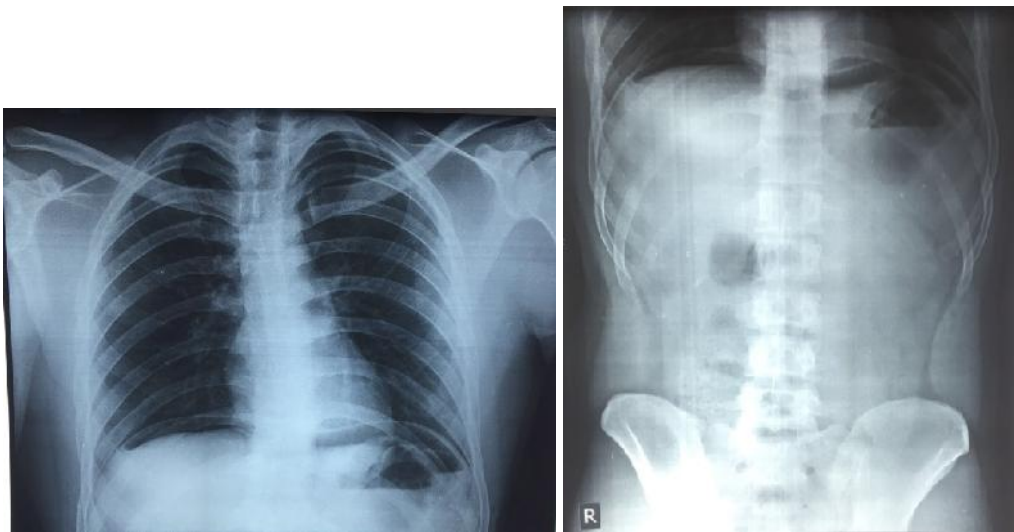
Chest X-ray and erect abdomen X-ray showing free gas under diaphragm
